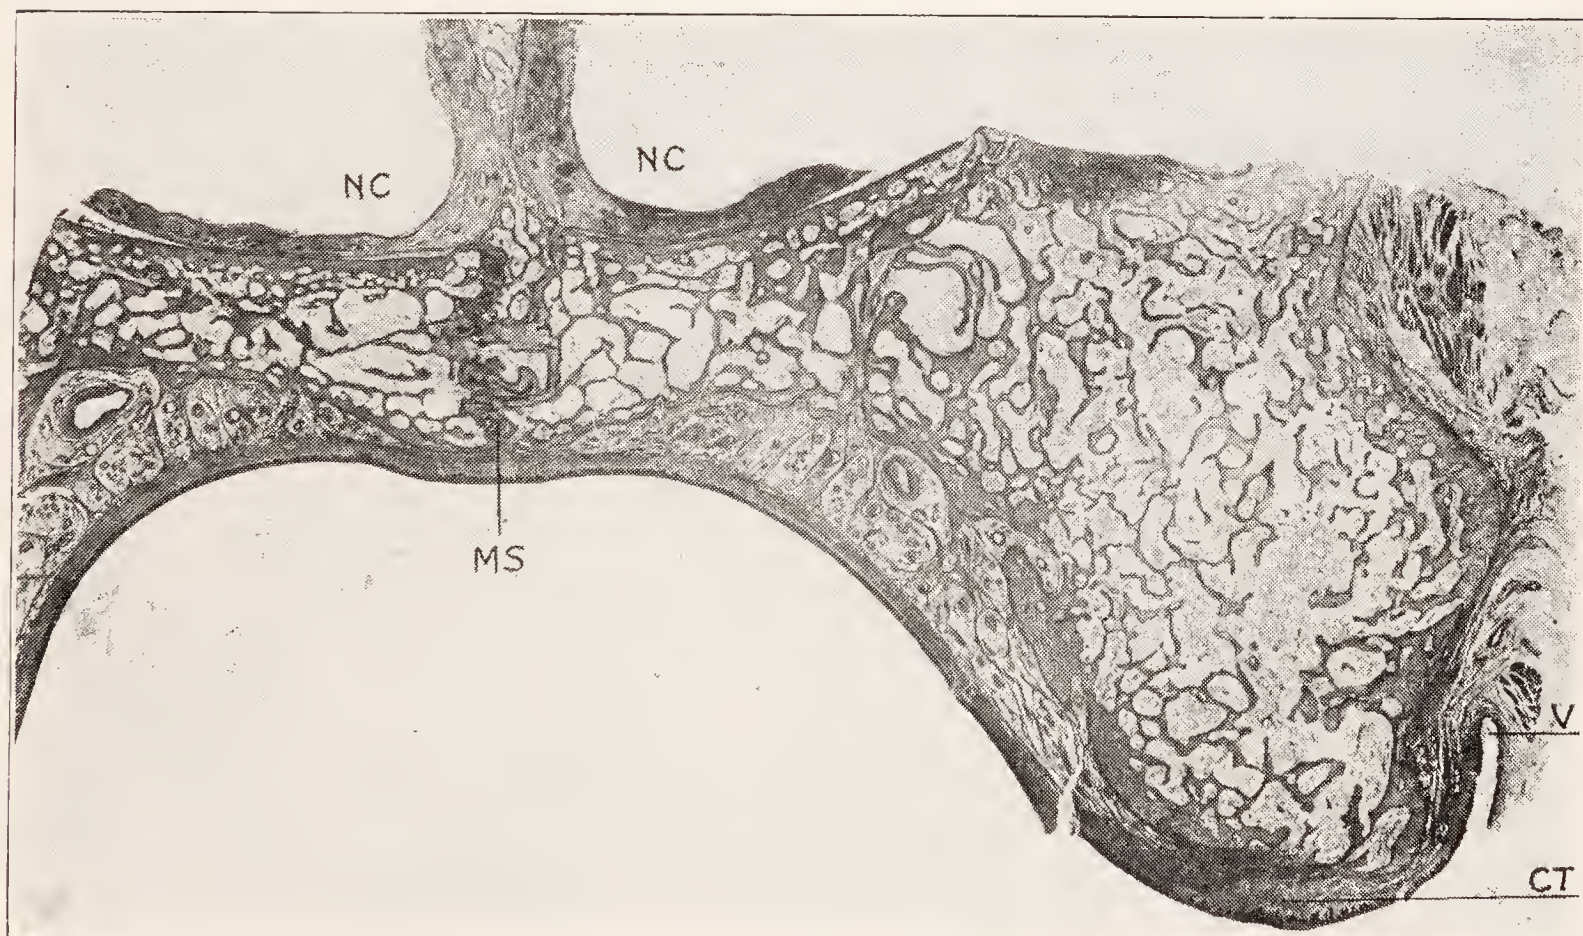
Frontal section through an edentulous maxilla in the region of the second bicuspid. NC, nasal cavity; MS, maxillary sinus; V, vestibulum; CT, connective tissue covering residual alveolar ridge.
